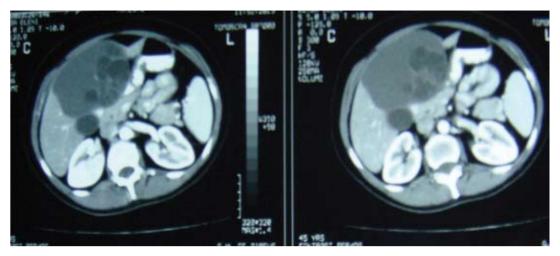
Abdominal CT showing a well demarcated multilocular thick walled cystic mass with internal septa. The diagnoses was hydatid cyst.
